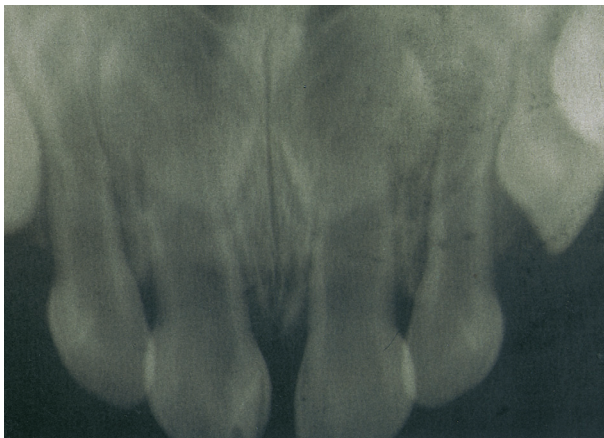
Periapical radiograph shows the talon cusp with pulpal extension.
